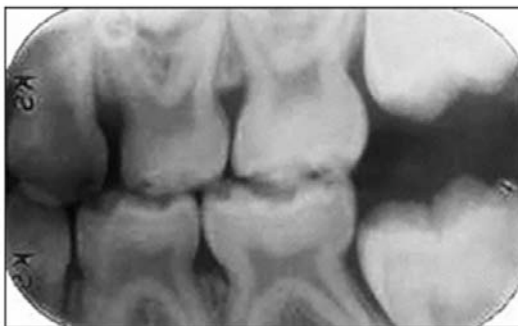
Bitewing radiograph of primary posterior teeth.
